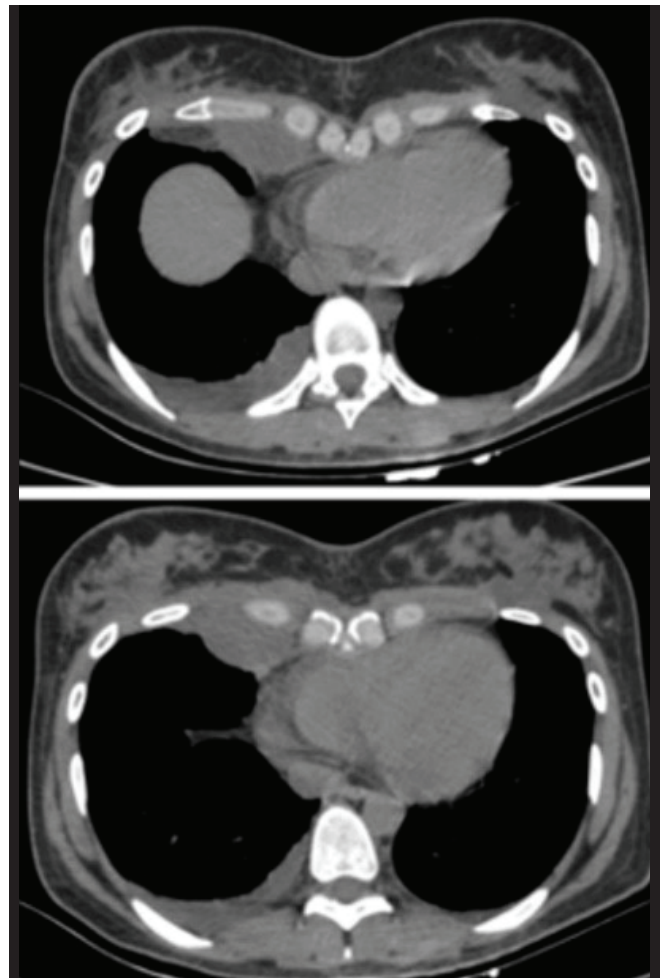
Thoracic CT scan showing a hypodense mass lesion in the right hemithorax, paracardiac region.
